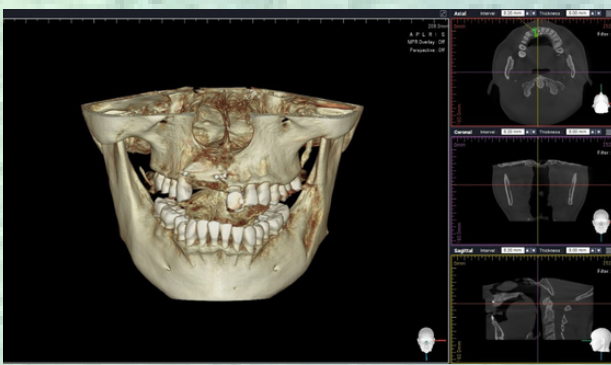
CBCT images 4 months after bone augmentation
